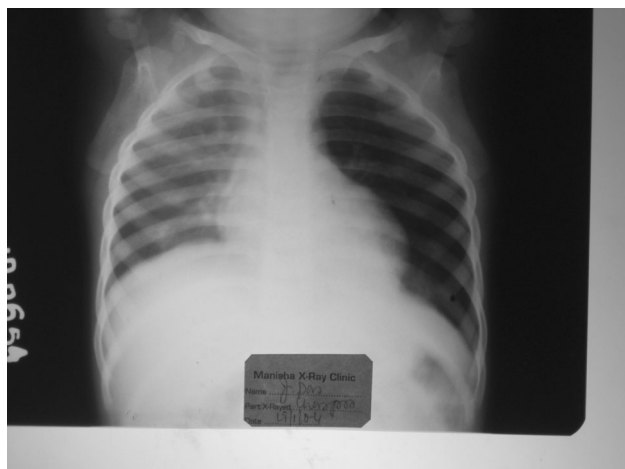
Chest radiograph showing collapse of *right* lung
